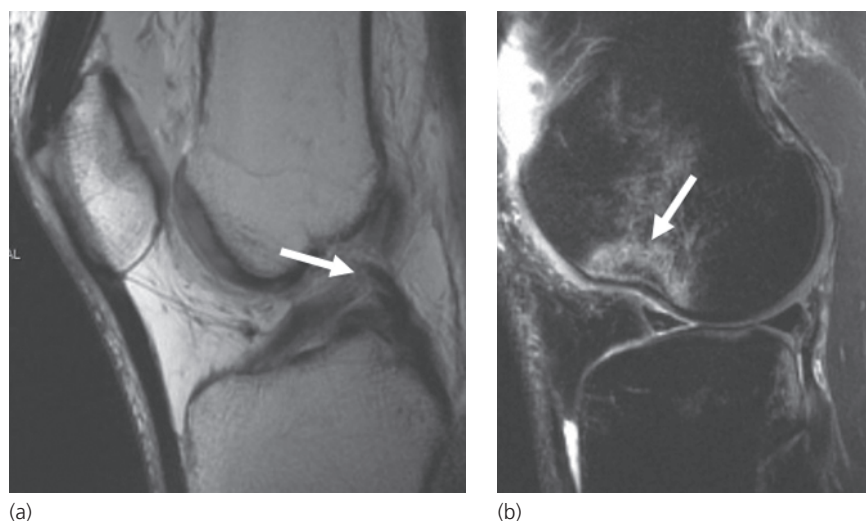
Anterior cruciate ligament injury and femoral condyle osteochondral impaction injury. (a) Sagittal proton density image shows a discontinuity in the mid ACL fibers (arrow). (b) Sagittal T2-weighted fat-suppressed image shows an impacted fracture at the level of the lateral sulcus (arrow).
